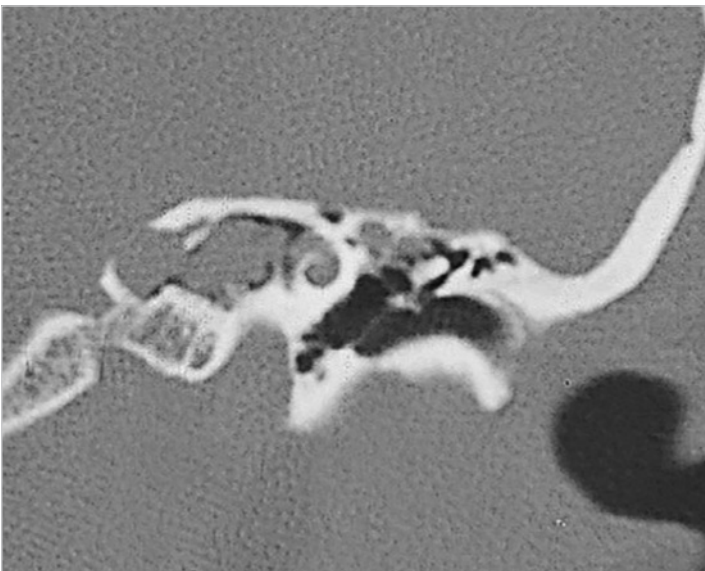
A more anterior section of the CT scan at the level of the cochlea. The internal auditory canal is completely infiltrated.
